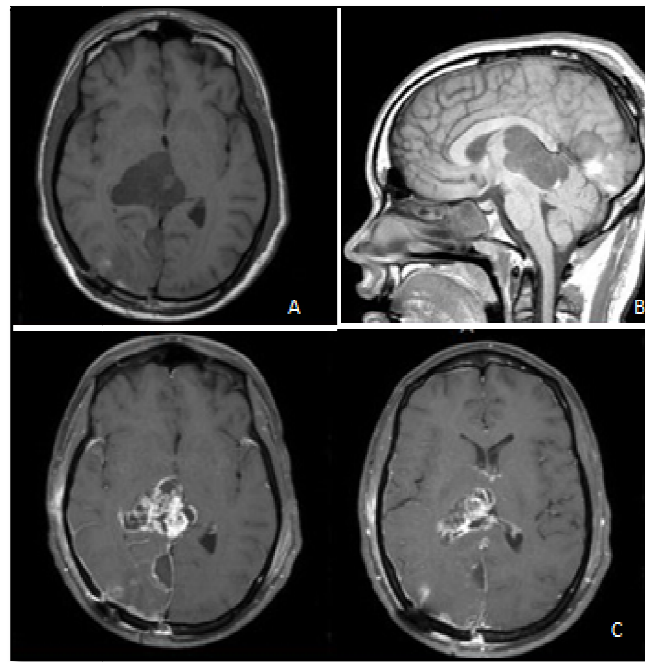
MRI of pineal extraskeletalmxoid chondrosarcoma after recurrence . Pre contrast T-1 weighted axial (A) and sagittal (B) images, and post contrast axial images (C)
